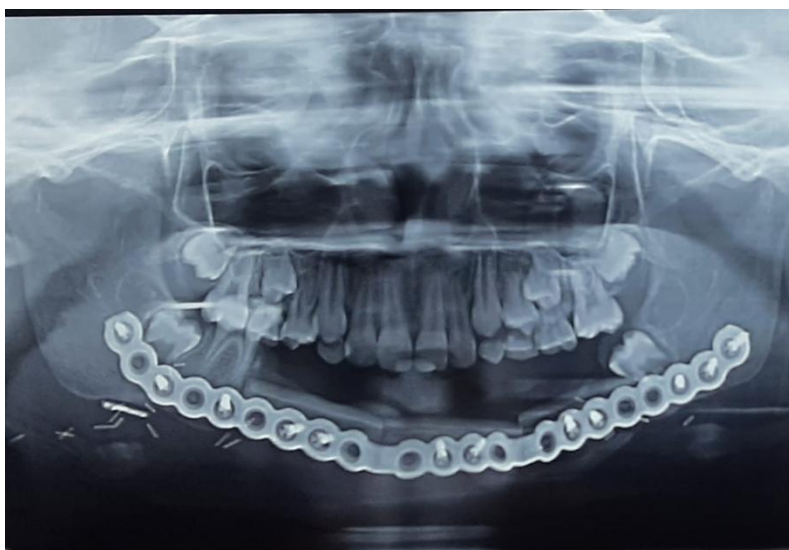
2 Xray of the fibula flap
